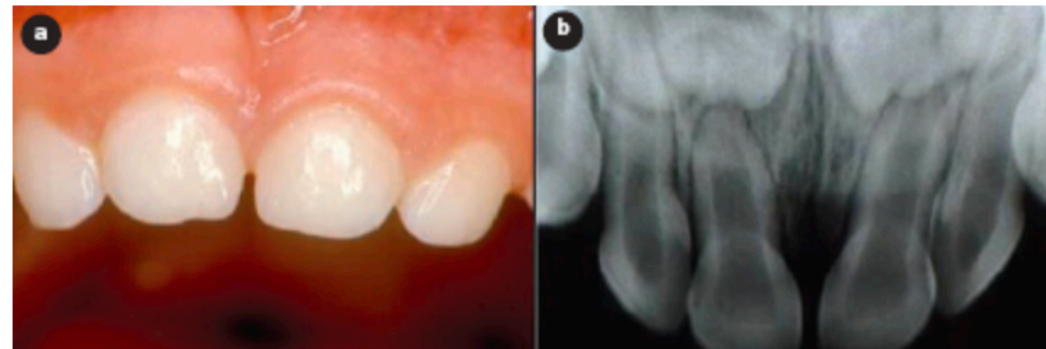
Clinical and radiographic views, 1 year after trauma: a) clinical examination revealed normal mucosa and no discoloration of the dental crown; b) radiographic examination showed normal characteristics.
